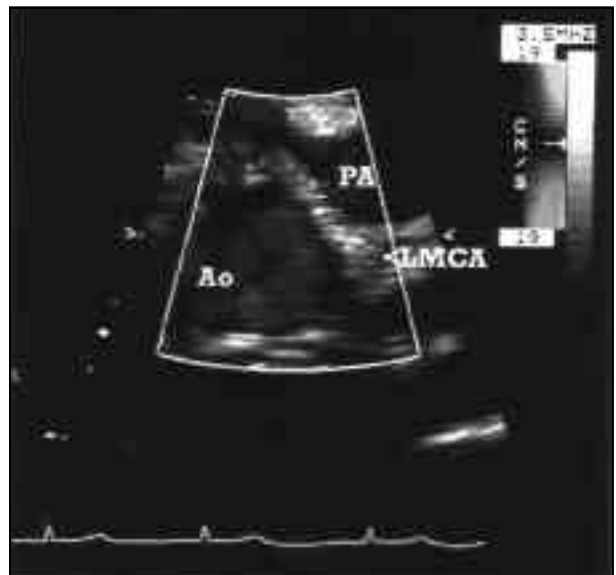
(B) Doppler color flow mapping in the same patient, which shows very slight color aliasing of the intramural segment of the left main coronary artery (LMCA).
